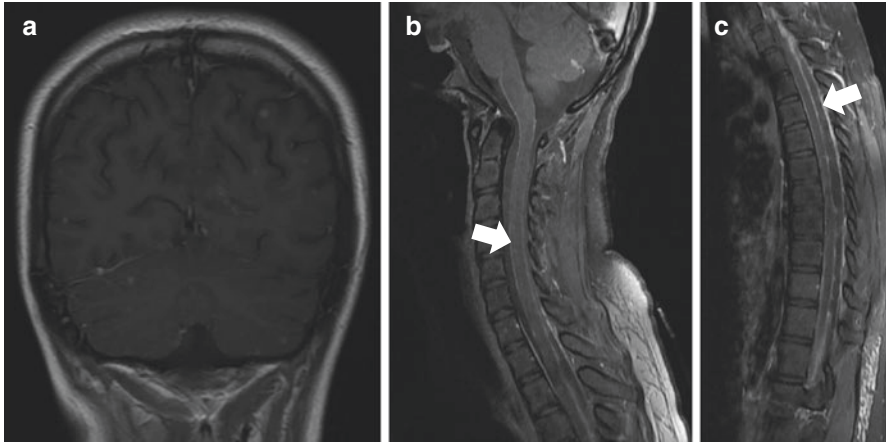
Patient with military TB and intradural disease. Coronal T1 post gadolinium MRI (a) demonstrates multiple foci of enhancement compatible with military disease. Sagittal fat-saturated T1 post contrast spinal MRI demonstrates leptomeningeal enhancement (solid arrow, b) and a peripherally enhancing dorsal subdural collection (solid arrow, c)
